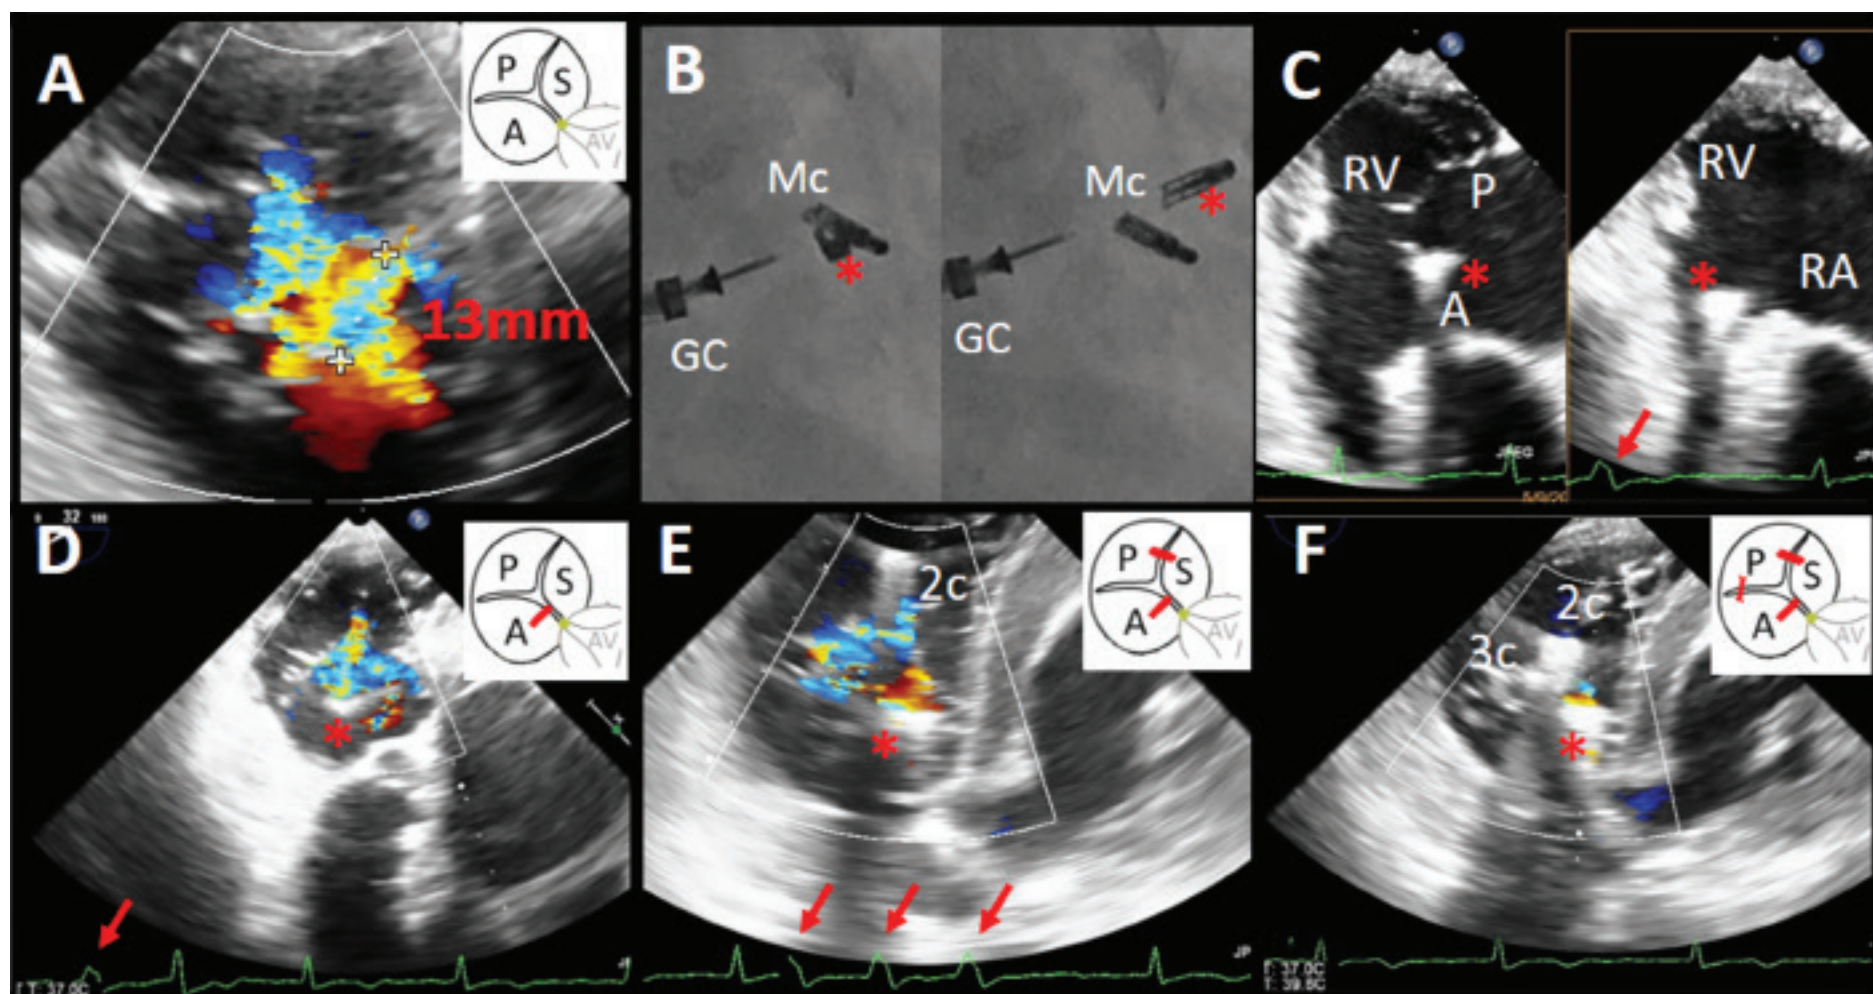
Transesophageal echocardiogram (TEE) and fluoroscopy images of single leaflet device attachment (SLDA) in MitraClip for tricuspid regurgitation (TR). (A) Baseline TEE at transgastric short-axis view showing the widest regurgitant orifice of TR is between the anterior and septal leaflets (A = anterior; S = septal; P = posterior leaflet; AV = aortic valve). (B) Fluoroscopy showing the flailing SLDA (* = SLDA clip; GC = guiding catheter; Mc = MitraClip placed at mitral valve). (C) TEE showing the flailing SLDA clip everted into the right atrium where it "hit" the right ventricle, triggering premature ventricular complex (RA = right atrium; RV = right ventricle; * = SLDA clip; PVC, red arrow = premature ventricular complex). (D) TEE showing significant tricuspid regurgitation after SLDA clip deployment and the presence of PVC (red arrow). (E) TEE after second clip placed at postero-septal commissure, showing partial stabilization of the SLDA clip and reduction of tricuspid regurgitation, but PVC persisted (red arrow = PVC; 2c = second clip). (F) Final TEE after third clip was placed at the antero-septal commissure, which stabilized the SLDA clip and resulted in further reduction of tricuspid regurgitation and cessation of ventricular arrhythmia (3c = third clip).
